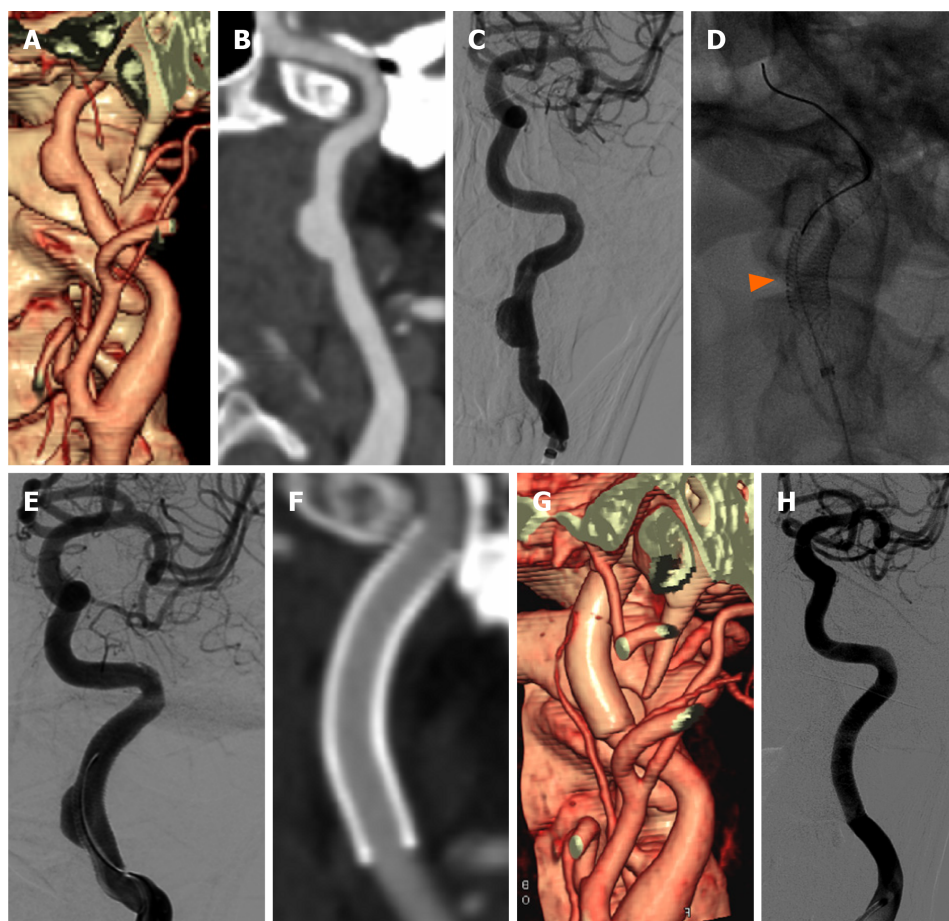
Case 1 was a 57-year-old male patient with sudden right limb weakness and vague speech and was diagnosed with cerebral infarction in February 2019. He was ultimately treated using a SUPERA stent. A: Cervical computed tomographic angiography (CTA) volume reconstruction; B: curved surface reconstruction show that the wide-necked dissecting aneurysm was situated on the upper segment of the left internal carotid artery; C: confirmed by digital subtraction angiography (DSA); D and E: The patient underwent SUPERA stent endovascular therapy, the arrow shows the dense stent mesh; F and G: Three months later, cervical CTA showed that the aneurysm had disappeared completely. H: One year later, DSA showed that the internal carotid artery was repaired perfectly.
